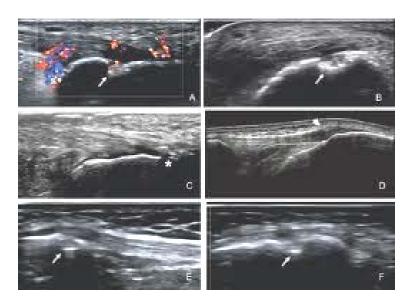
Ultrasound shows knee enthesitis
